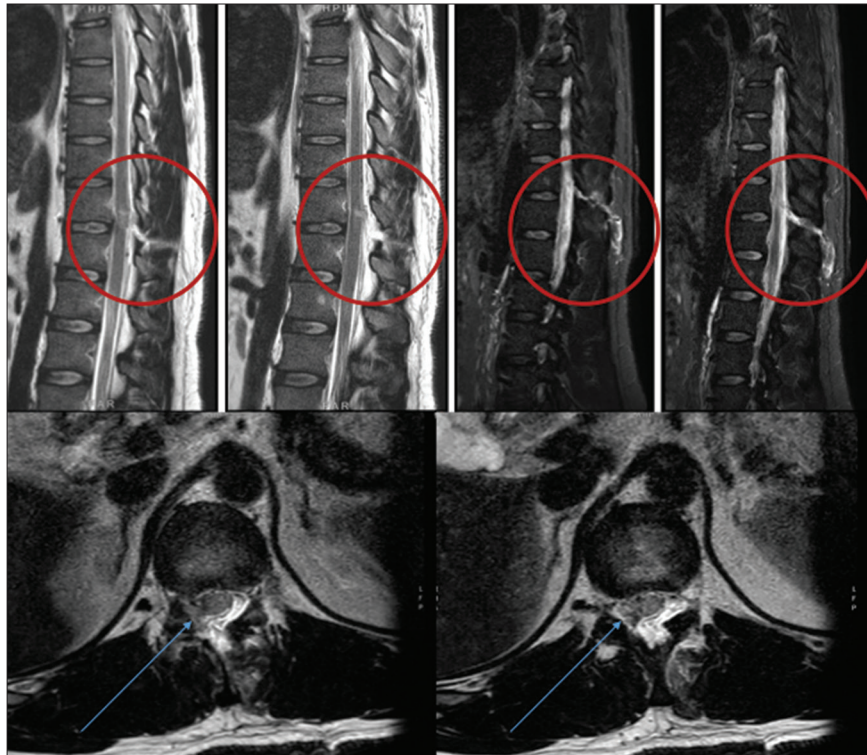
Spinal magnetic resonance imaging of patient 2, sagittal and axial scans. Red circles indicate the laceration of the yellow ligament and the interspinous ligament with signs of a cerebrospinal fluid fistula (hyperintensity in the short-tau inversion recovery sequences and a small fluid collection in the subcutaneous tissue). Blue arrows indicate the lesion on the posterior-lateral side of the thecal sac.
